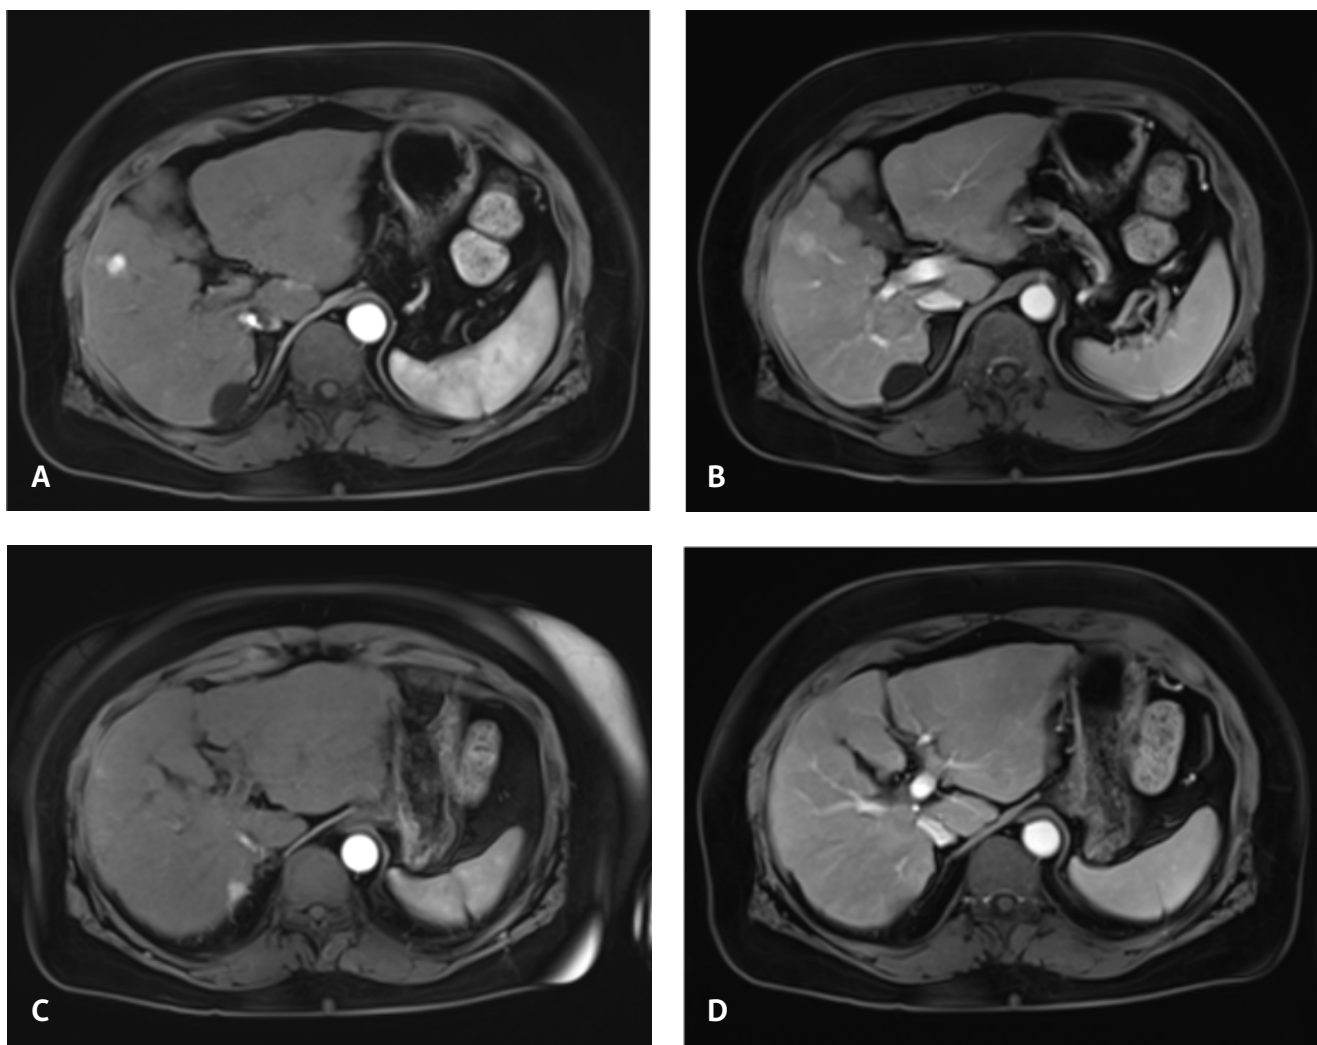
MRI of the abdomen with contrast characterized 2 hepatic lesions: a 1.5 x 1.0 cm segment 5 LR-5 lesion with (A) enhancement on the arterial phase and (B) washout on the venous phase; and a 1.2 x 0.8 cm segment 7 LR-5 lesion with (C) enhancement on the arterial phase and (D) washout on the venous phase.
